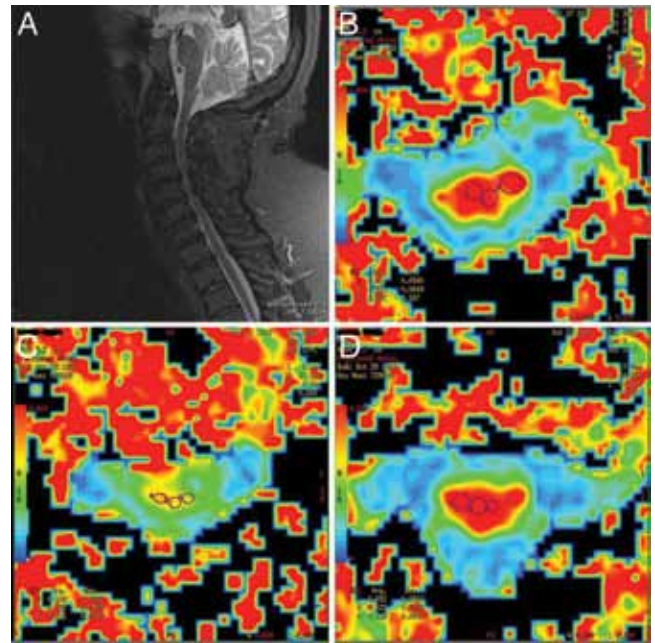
Sagittal MR imaging study of the cervical spine in the same patient reveal signal change within the spinal cord on the STIR sequence (A) due to severe CSS. The DT imaging studies demonstrate marked reduction of FA values within the stenotic region (C) compared with C2–3 (B) and C7–T1 (D), which is suggestive of axonal injury.
